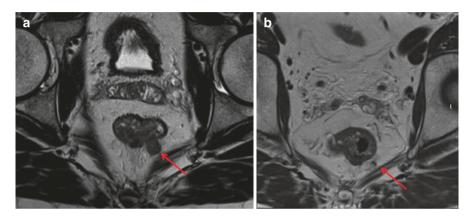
(a) Baseline MRI showing a low/mid rectal tumour involving the rectal wall at 4–7 o'clock with evidence of spread beyond the muscularis propria (arrow). A contiguous EMVI of the mid rectal vein at 5 o'clock position extends up the mesorectal fascia suggesting CRM+ve disease (overall mrT3dN1cEMVI+ve CRM+ve). (b) The same patient post CRT MRI. Tumour shows good response to treatment (arrow) with only linear fibrosis identified at the site of the treated disease and an area of low signal/fibrosis at the site of the contiguous EMVI (5 o'clock position), (overall Stage mrT2N0EMVI-ve CRM-ve TRG2 if any viable tumour left)
